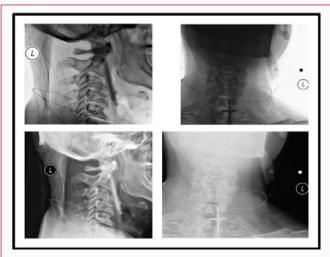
Neck x-ray showing a glass foreign body in the left neck.
